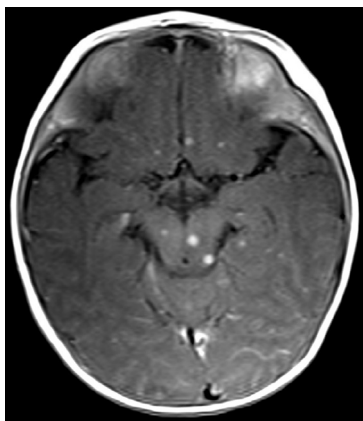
Contrast-enhanced axial T1 weighted image of the brain magnetic resonance imaging shows supratentorial and infratentorial multiple enhancing parenchymal nodules consistent with tuberculomas.
